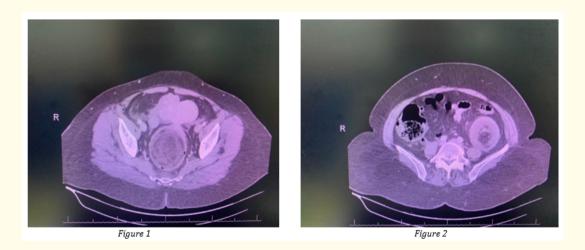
CT abdomen showing thickening of the colonic wall in which a lower attenuated middle layer is surrounded on each side by layers of higher attenuation (target sign).
